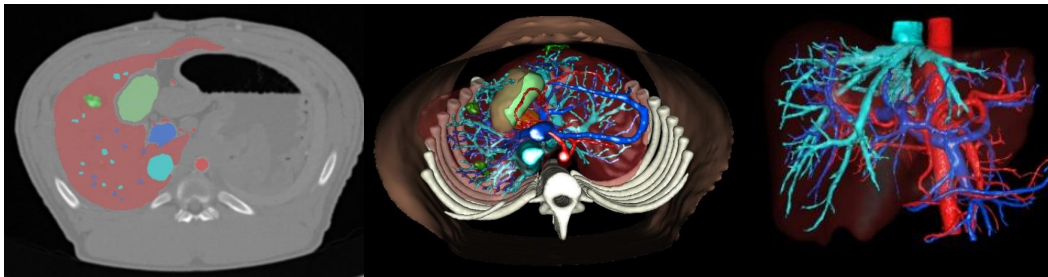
Segmentation of the liver in magenta, arterial vessels in red, portal and hepatic networks in light blue and dark blue respectively, surrogate tumors in dark green and gall bladder in light green. (*Left*): Overlay of the segmented areas on pre-operative CT image. (*Middle*): Creation of the 3D model. (*Right*): Vessels and liver parenchyma.
